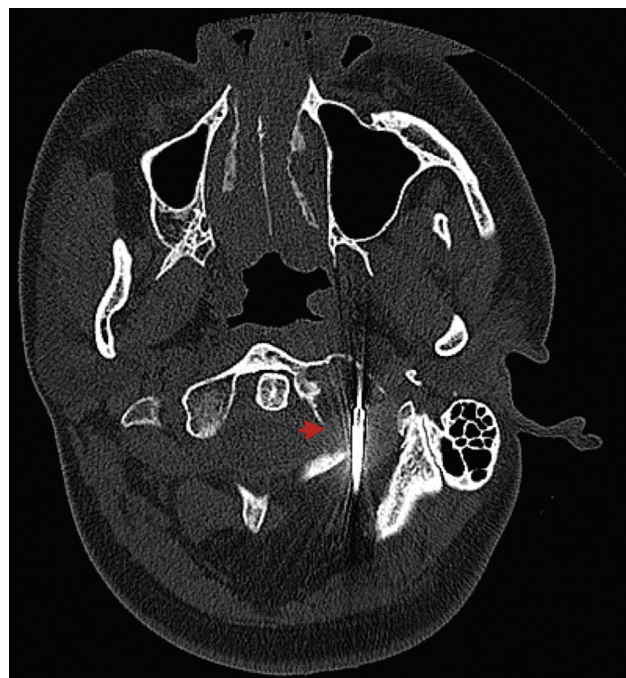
Percutaneous puncture biopsy of the atlas guided by computed tomography scanner.
